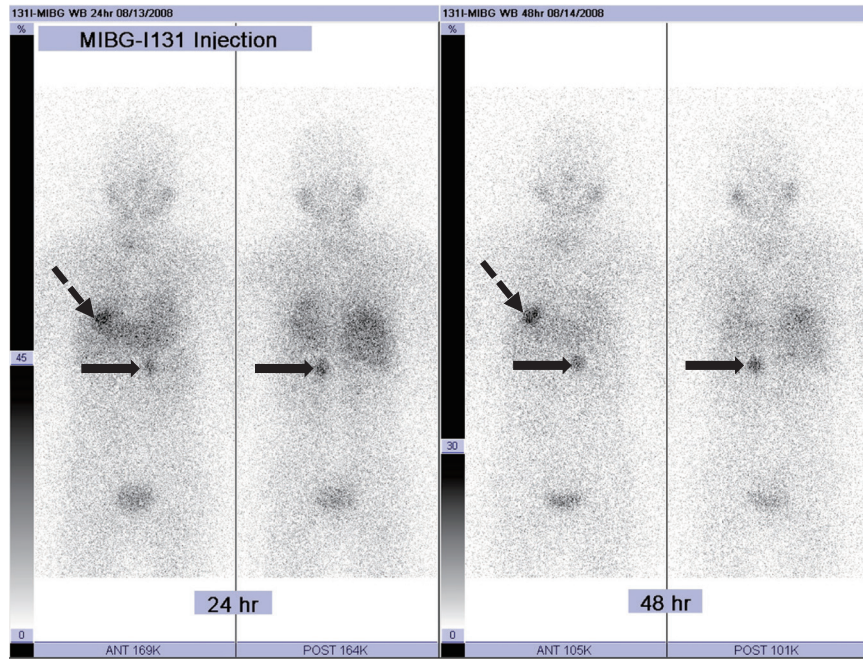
Iodine 131-labeled metaiodobenzylguanidine scintigraphy shows involvement of the left adrenal gland and the liver. Black arrows indicate the left adrenal tumor, and black broken arrows indicate the liver tumor. These findings suggest PCC of the left adrenal gland and liver metastasis of MTC.
